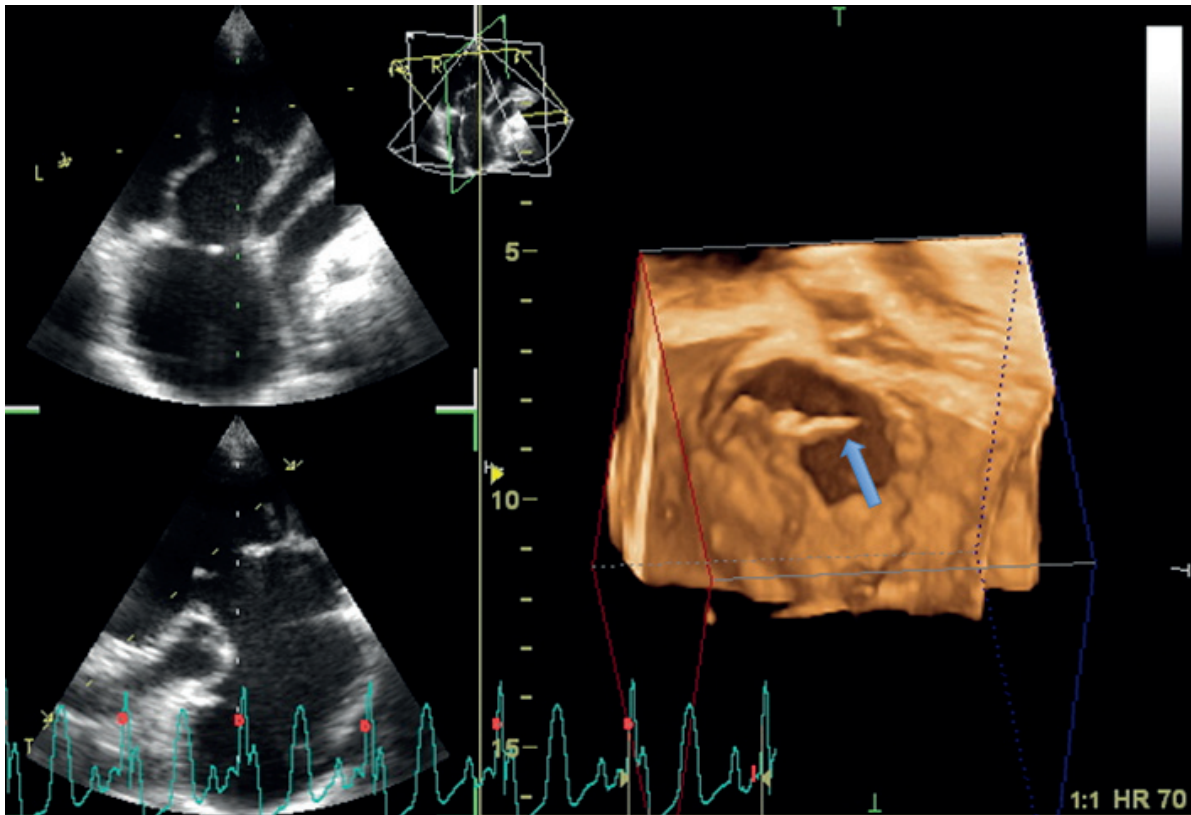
3-D echocardiography. 3-D reconstruction of the tricuspid valve (before surgical reconstruction) for an 11-year-old girl with Ebstein's anomaly, a free-floating leaflet (blue arrow), and chordal rupture.
